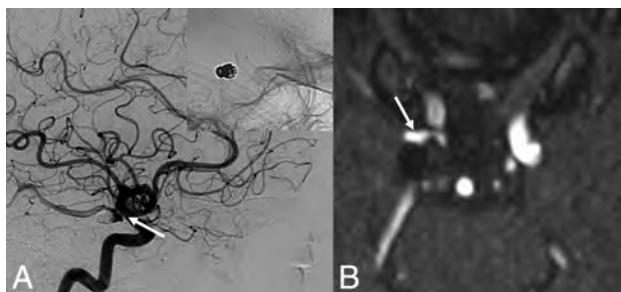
Aneurysm persistence after flow diversion. A 67-year-old woman who had a previously ruptured right posterior communicating artery aneurysm with evidence of recanalization on the 6-month follow-up angiogram. She was treated with flow diversion for the neck recurrence. A 6-month follow-up DSA (lateral x-ray) after flow diversion demonstrates class C OKM grade (continued filling at the neck of the aneurysm) (*white arrow*). At last clinical and angiographic follow-ups at 3 years, there is no evidence of aneurysm rerupture or progression of the neck remnant on MRA (*white arrow*).
